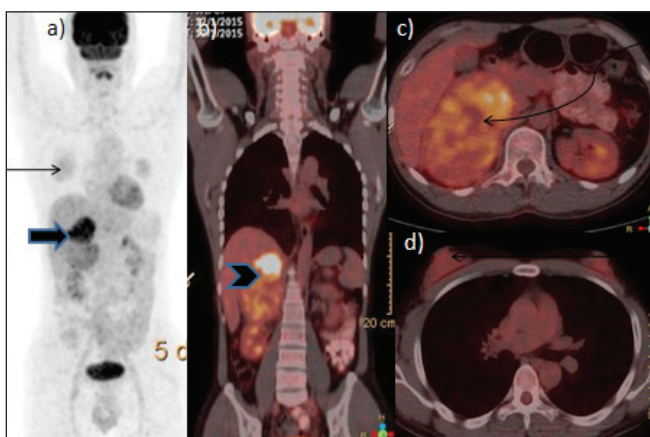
MIP (maximum intensity projection) image (a) demonstrates mild diffuse uptake in bilateral breasts, right greater than left (arrow on right) and the right adrenal tumor mass (broad arrow) [Figure (3a)]. [Figure (3b), (3c), (3d)] are fused PET/CT images. [Figure (3b)] shows the coronal section of the right adrenal mass (arrow head), [Figure (3c)] shows the axial sections with increased tracer uptake in the right adrenal mass (curved arrow) and [Figure (3d)] shows axial sections with increased FDG uptake in dense parenchyma of enlarged bilateral breasts suggestive of gynecomastia (arrow on right gynecomastia)
